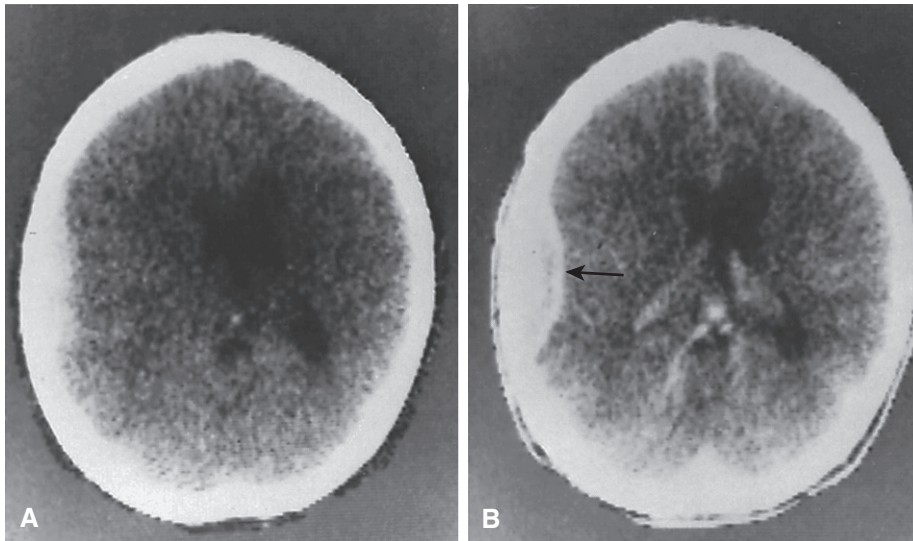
Computed tomography (CT) of epidural hematoma. A, Plain CT scan shows parietal epidural hematoma. B, Contrast-enhanced CT scan shows enhancing dural rim (arrow). (From Haaga JR, Alfidi RJ [eds]: *Computed Tomography of the Whole Body, Vol 1*. St. Louis, Mosby, 1983, p 185.)
